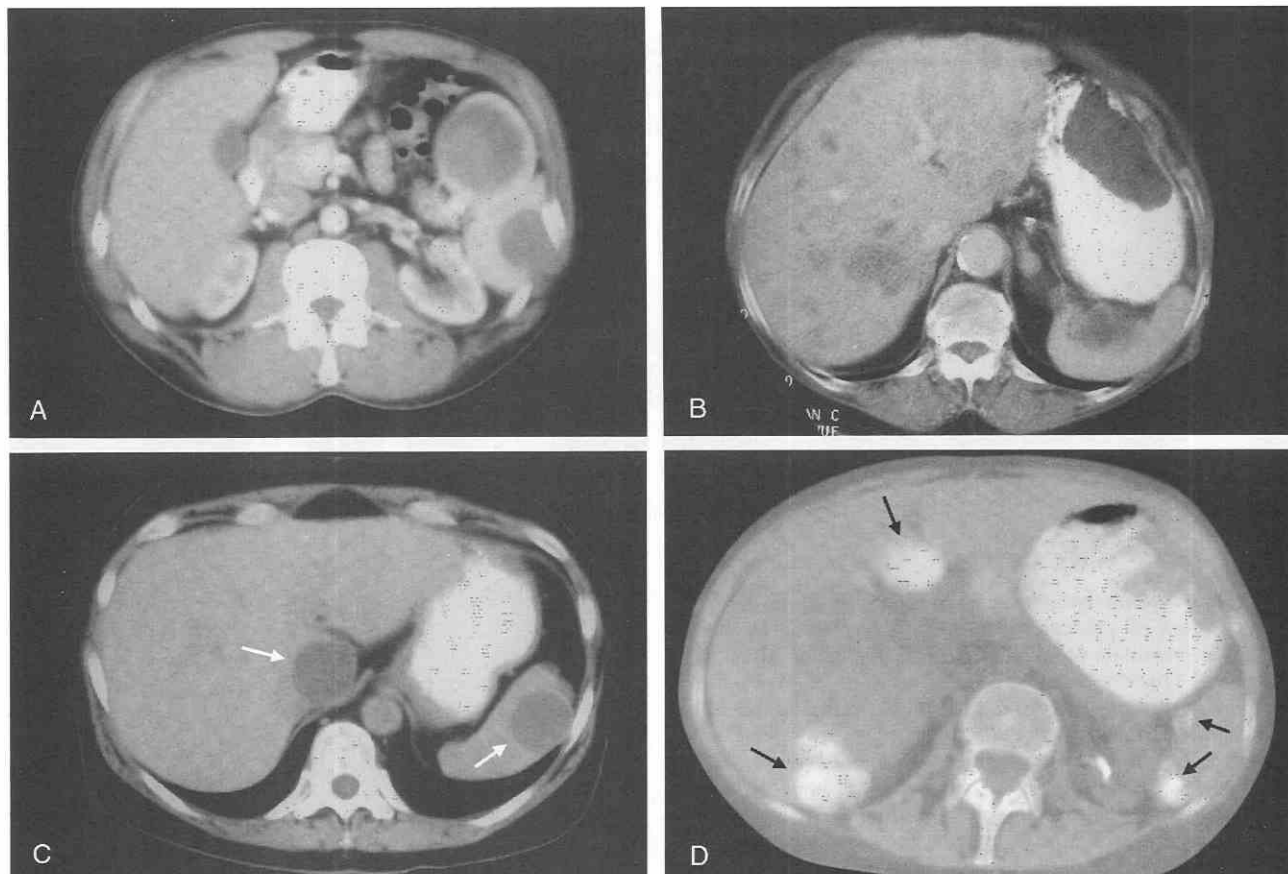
CT scans showing spleen metastases. *A*, Low-attenuation melanoma metastases to the spleen. *B*, Low-attenuation breast cancer metastases to the spleen, liver, and left adrenal gland. *C*, Ovarian carcinoma with cystic spleen and liver metastases (arrows). *D*, Ovarian carcinoma with calcified spleen and liver metastases after treatment (arrows).
